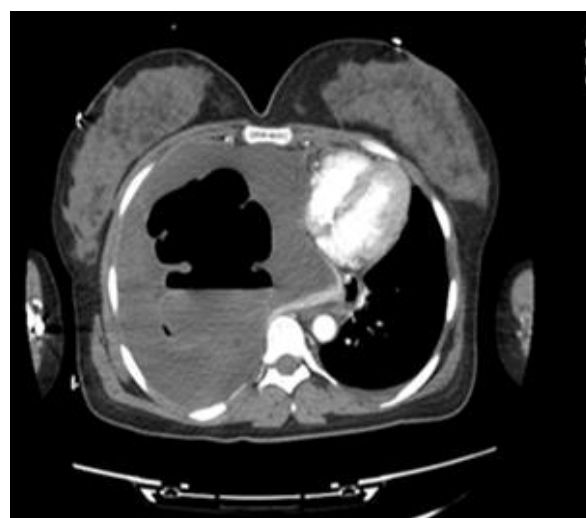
The herniation of the intestinal loops to the thorax at the axial CT
